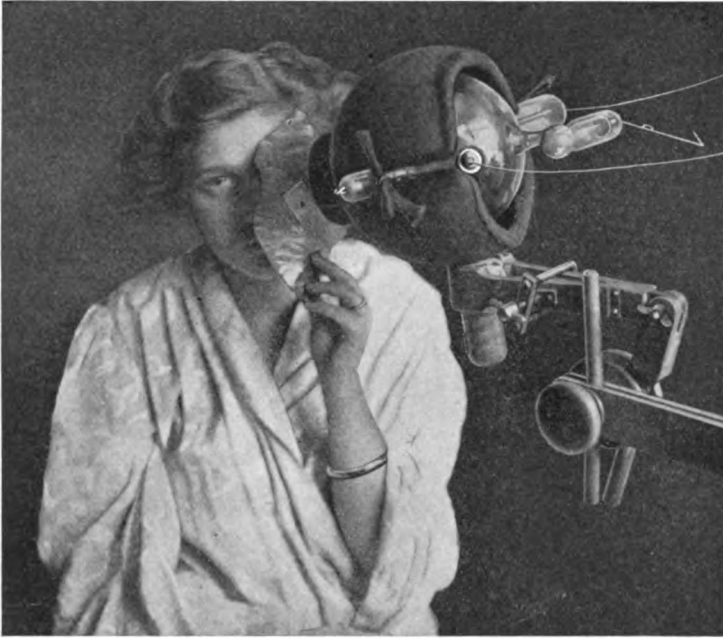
Technic of Röntgenotherapy for epithelioma of face. Tube in a localizing shield; perforated sheet of x-ray metal securely fastened to the surface by adhesive plaster.
